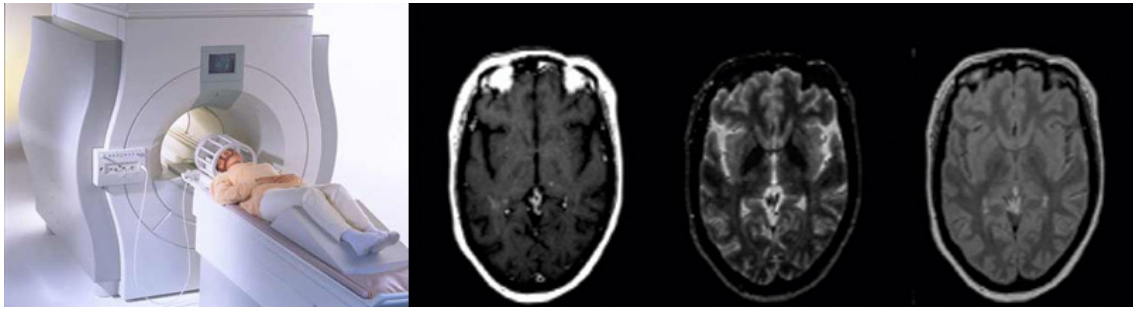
Magnetic Resonance Imaging: MRI Scanner, MR-T1, MR-T2, and MR Proton Density.
